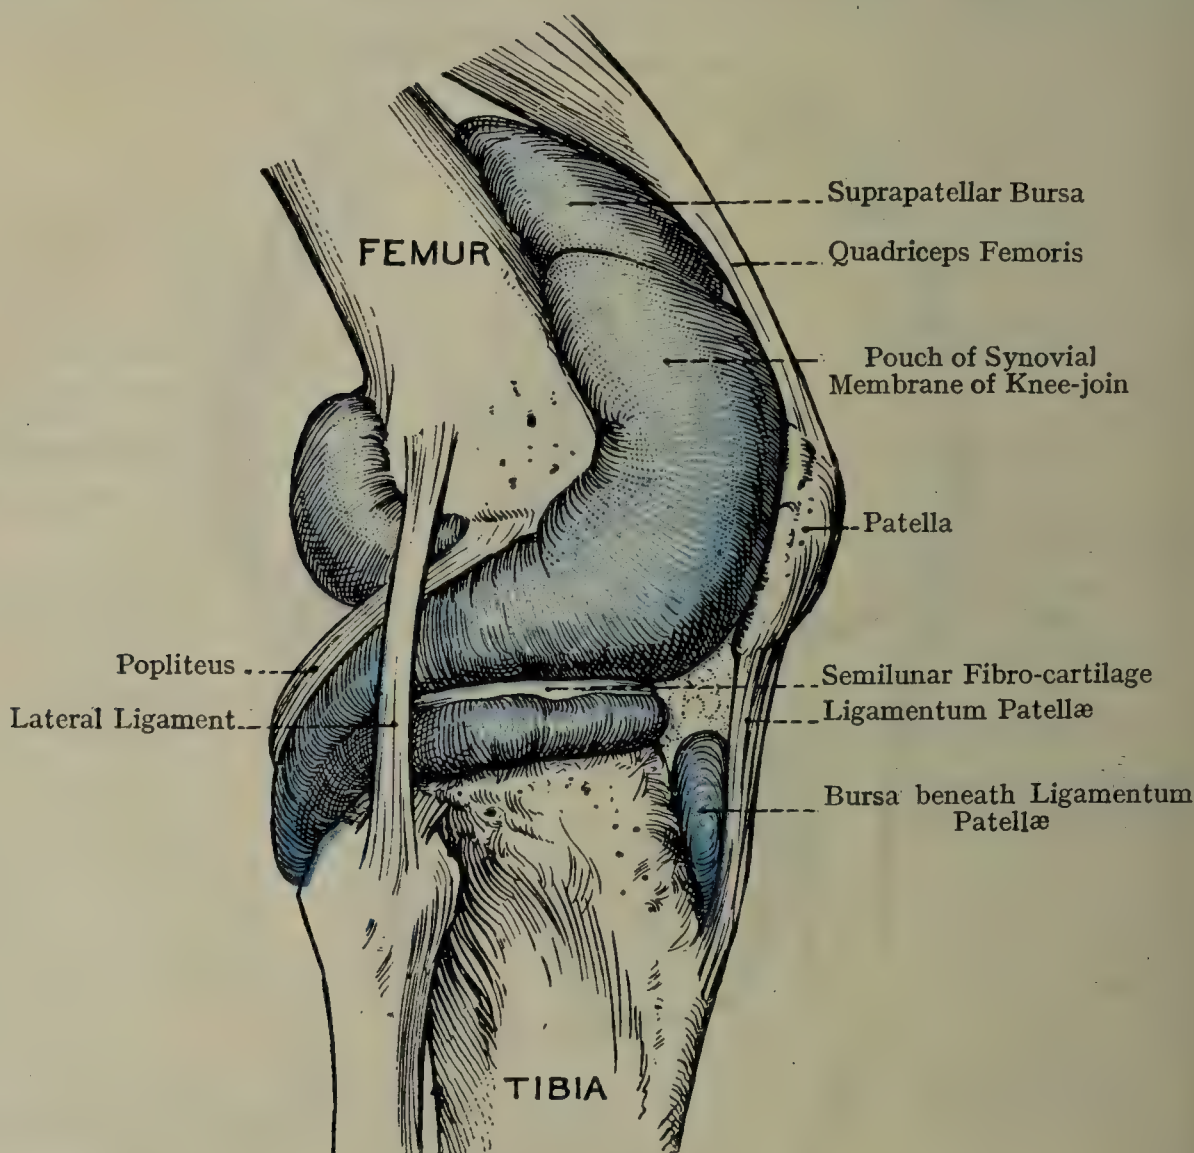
THE SYNOVIAL MEMBRANE OF THE RIGHT KNEE-JOINT (LATERAL ASPECT) (AFTER SPALTEHOLZ).
